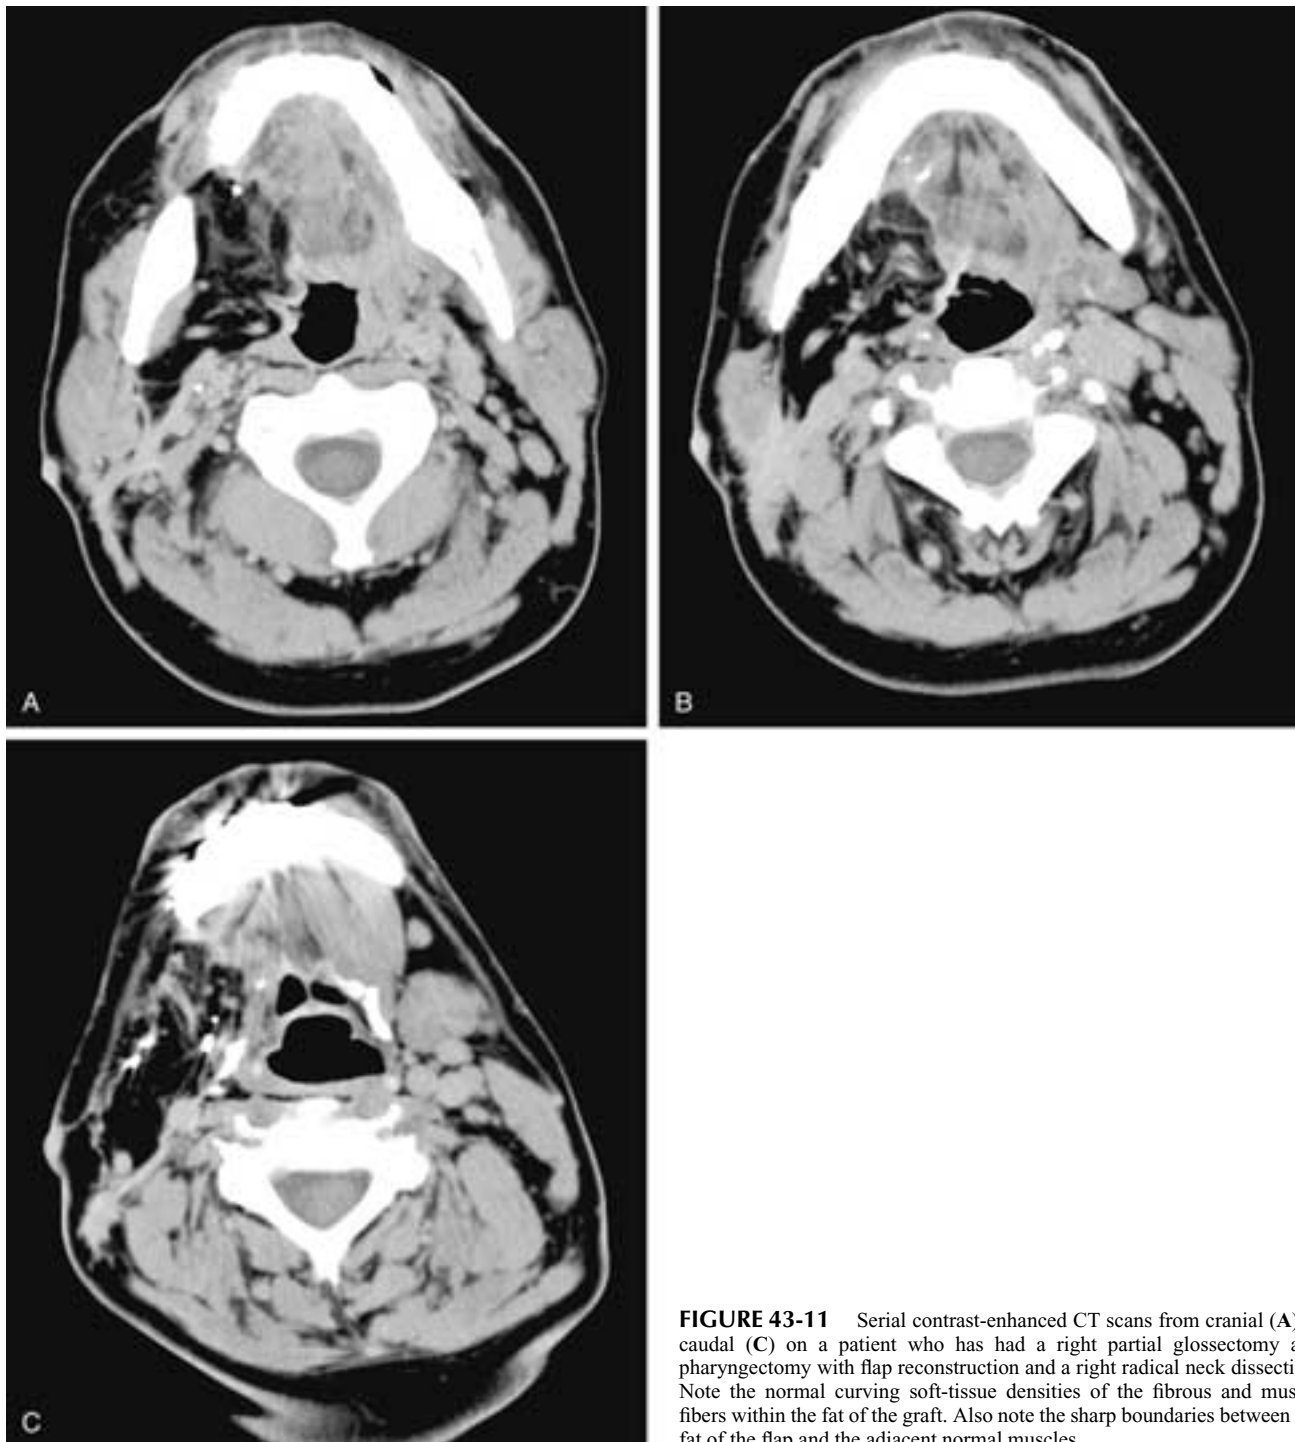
Serial contrast-enhanced CT scans from cranial (A) to caudal (C) on a patient who has had a right partial glossectomy and pharyngectomy with flap reconstruction and a right radical neck dissection. Note the normal curving soft-tissue densities of the fibrous and muscle fibers within the fat of the graft. Also note the sharp boundaries between the fat of the flap and the adjacent normal muscles.
